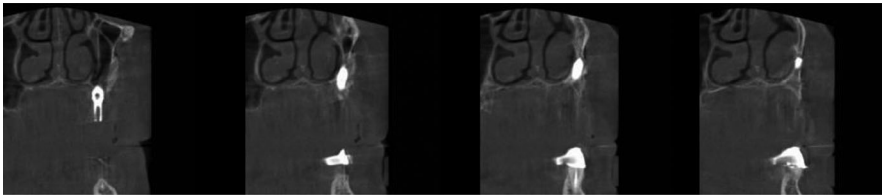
The CBCT at the level of the right trans-crestal tilted implant showed that the implant is placed entirely in the residual bone.
